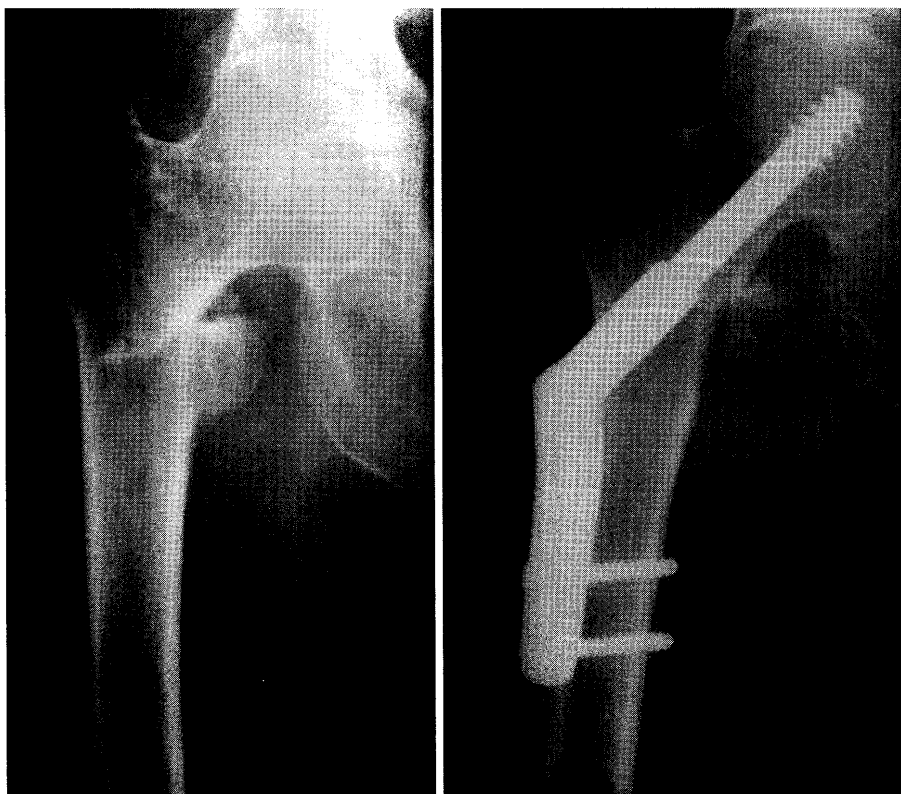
Radiograph 135° CHS
